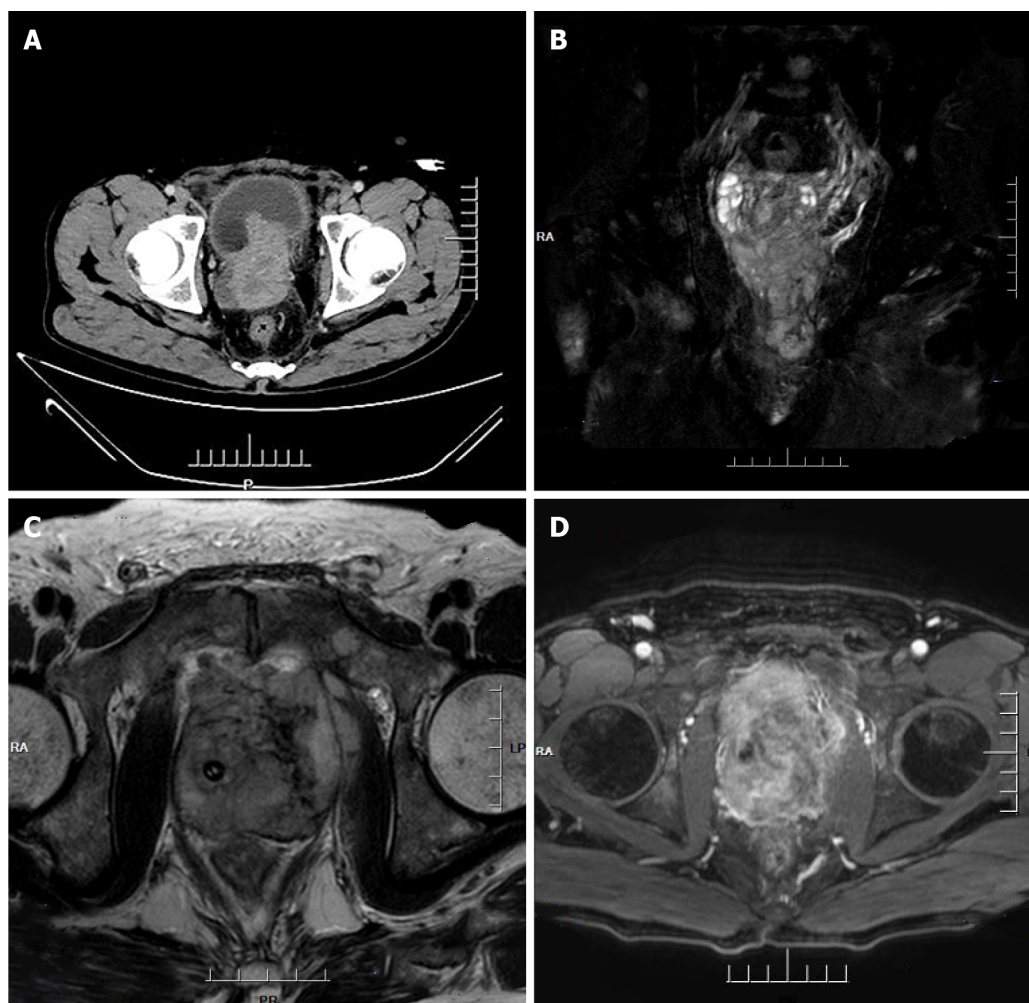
Computed tomography imaging and magnetic resonance imaging. A: Computed tomography imaging of the abdomen: Heterogeneous density within the prostate and heterogeneous enhancement after enhancement, suggesting possible prostate cancer, possible pelvic lymph node metastasis, pelvic floor fascia, and rectal wall and seminal vesicle invasion; B-D: Prostate magnetic resonance imaging: Mixed signals in the prostate, with possible prostate tumor invasion of the lower posterior bladder wall, rectal mesentery, and bilateral seminal vesicles, with multiple lymph node metastases in the pelvis.
